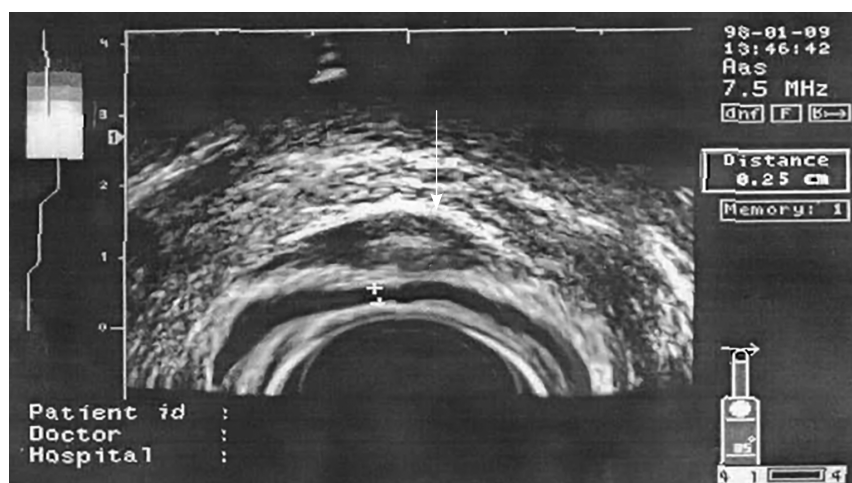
Endosonogram of the anal canal of a child with hypertrophy of internal anal sphincter, internal sphincter thickness – 2.5 mm
